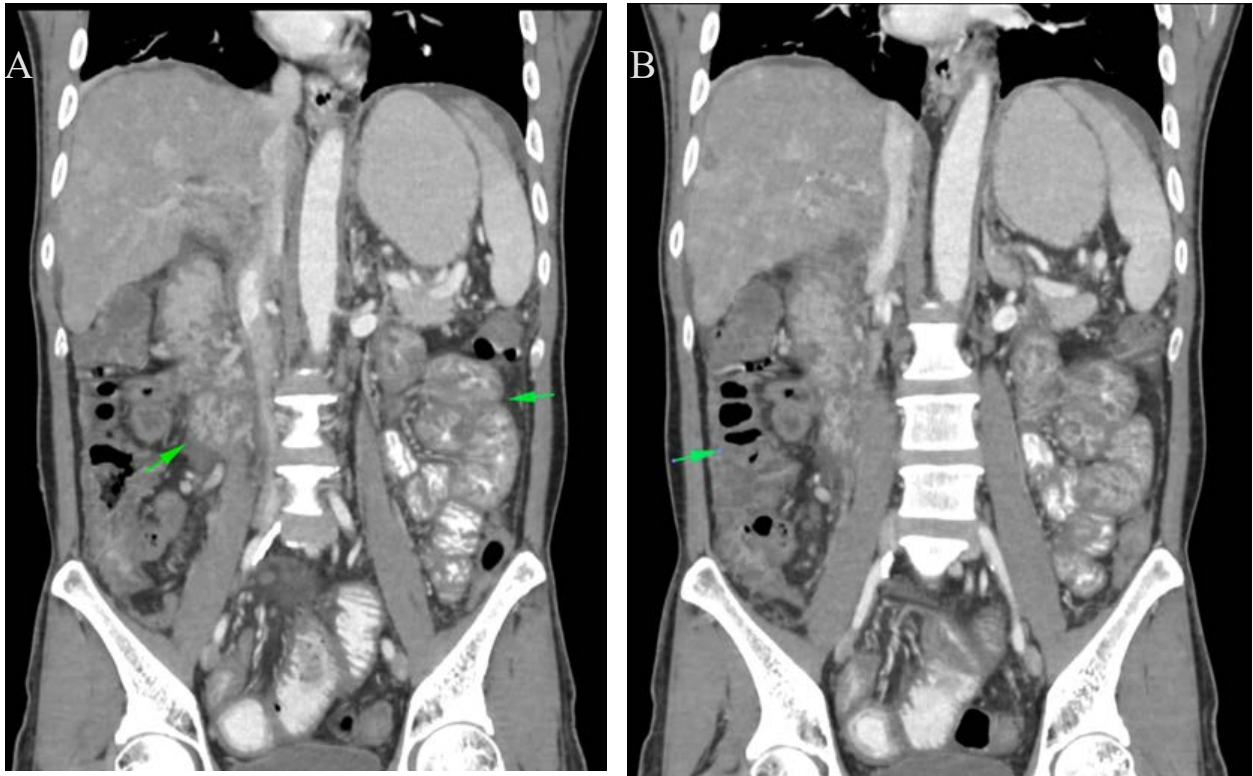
Coronal (A and B) contrast-enhanced CT image demonstrates Bowel wall thickening of the jejunum, ileum, and ascending colon with fat stranding.;
